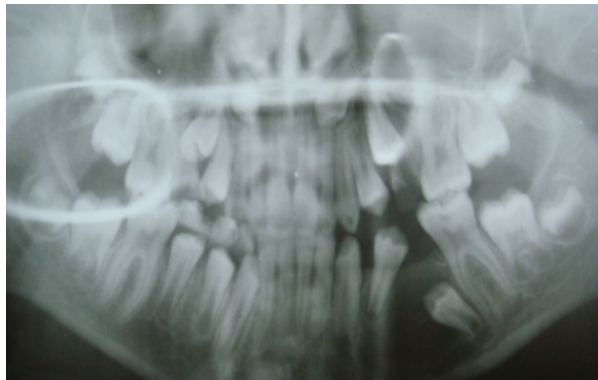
Panoramic radiograph taken eight months after extraction of mandibular left primary second molar
